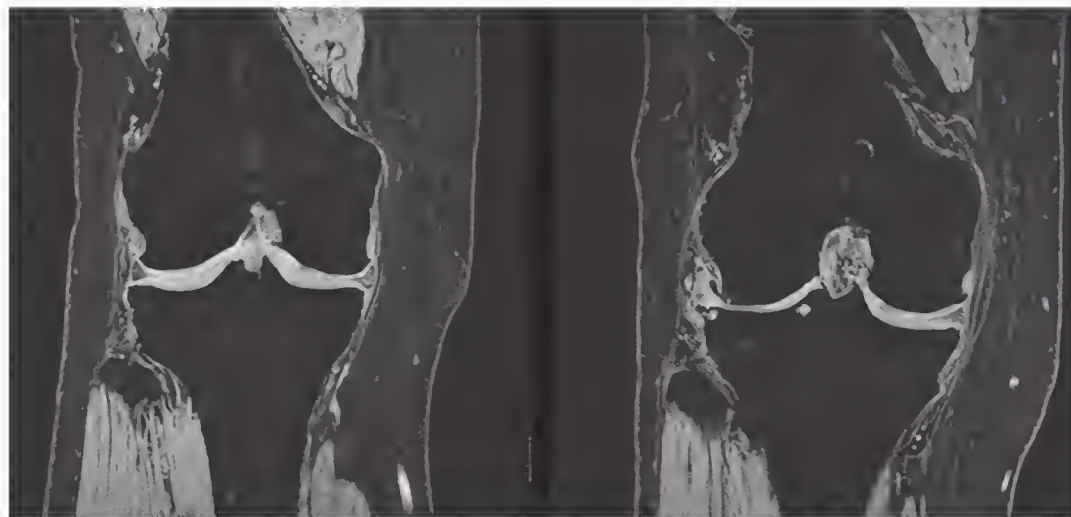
Coronal magnetic resonance imaging data sets of the knee acquired using a fast low-angle shot (FLASH) or spoiled gradient echo (SPGR) sequence. This imaging sequence has been extensively validated for detecting cartilage lesions and for performing quantitative measures of cartilage volume and thickness. The left image shows a healthy knee with normal cartilage thickness, the right image a knee with osteoarthritis. Note the osteophytes and the extensive cartilage loss in the lateral femorotibial compartment. (Courtesy Felix Eckstein, Salzburg, Austria.)
